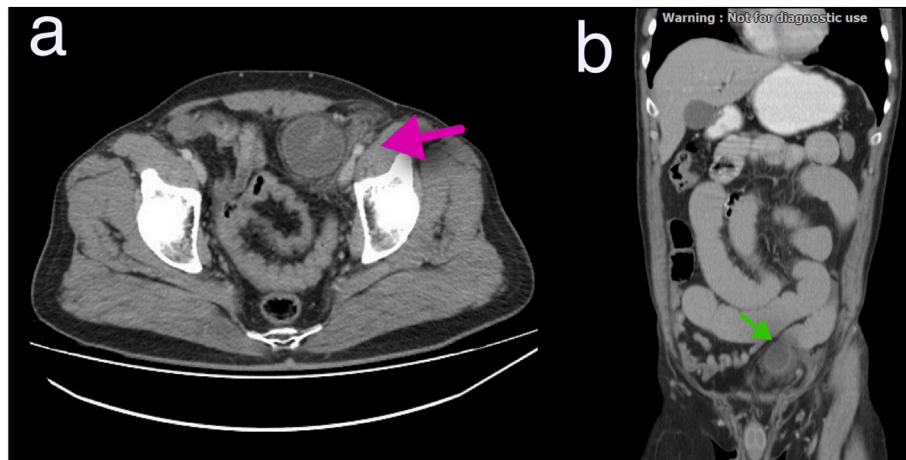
CT images of the patient. a) a ball-like loop of jejunum (pink arrow) in the left lower quadrant is seen in axial view. b) coronal views shows the same features. (For interpretation of the references to color in this figure legend, the reader is referred to the web version of this article.)
